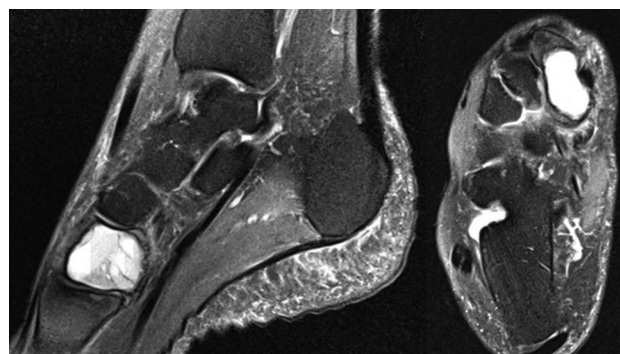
MRI scans of the right foot showing a multiloculated expansile lytic lesion with multiple thin septations and typical fluid-fluid levels due to blood sedimentation
